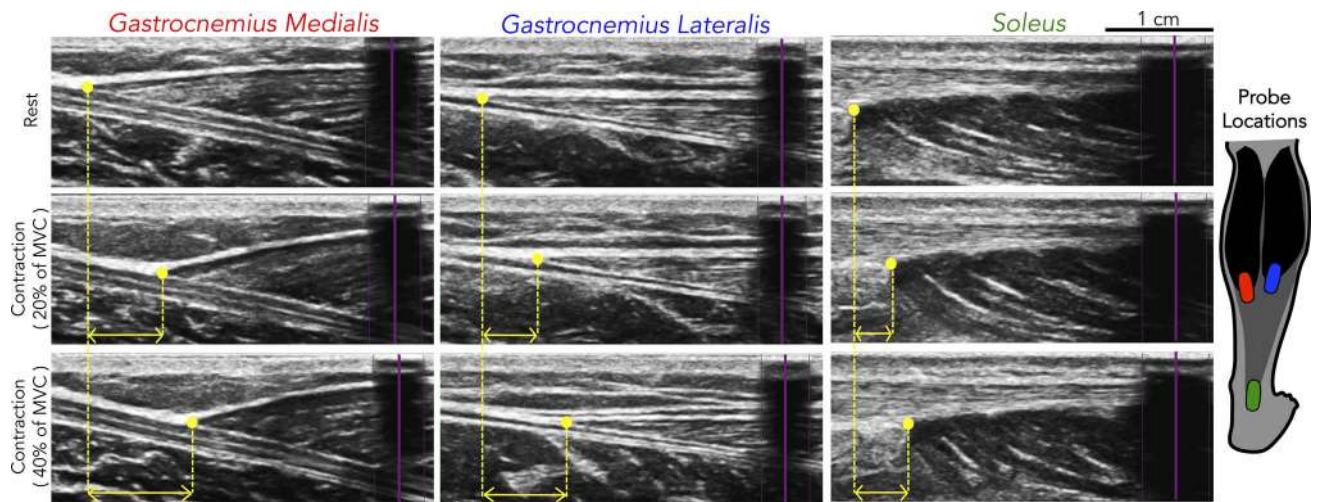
Typical example of ultrasound images used for the tracking of the myotendinous junction. Ultrasound images are depicted for the relaxed state (top images) and the two contraction intensities (20% and 40% of MVC). The myotendinous junction is shown by the yellow dot. Each myotendinous junction was tracked manually using a custom-made program. A hypoechoic tape was used as a reference landmark, and it is visible as the *large black strip* (highlighted in purple, within each of the ultrasound images). The *double yellow arrow* represents the displacement of the myotendinous junction of each muscle. The location of the ultrasound probe placement relative to the calf is shown in the right image.
